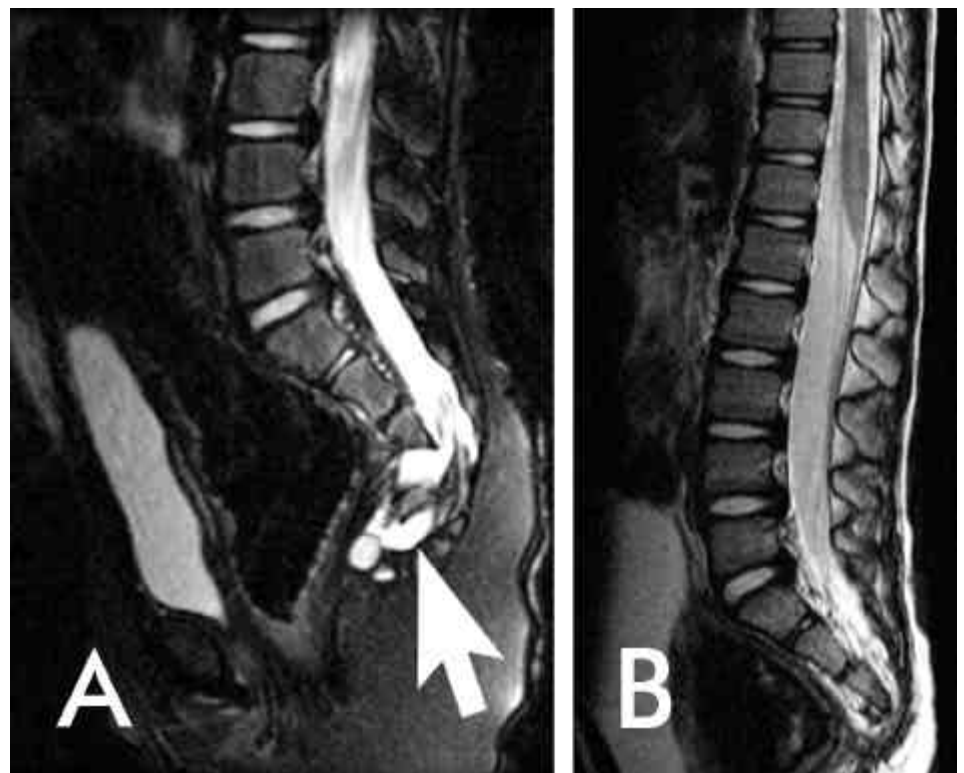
Currarino's triad revealed in T2-weighted magnetic resonance images before and after surgery. A. The lumbosacral spine and pelvis demonstrate an anterior sacral meningocele and small, round, hyperintense mass inferiorly (arrow). The rectum and bladder appear distended. B. The meningocele and associated soft-tissue mass have been totally resected.
